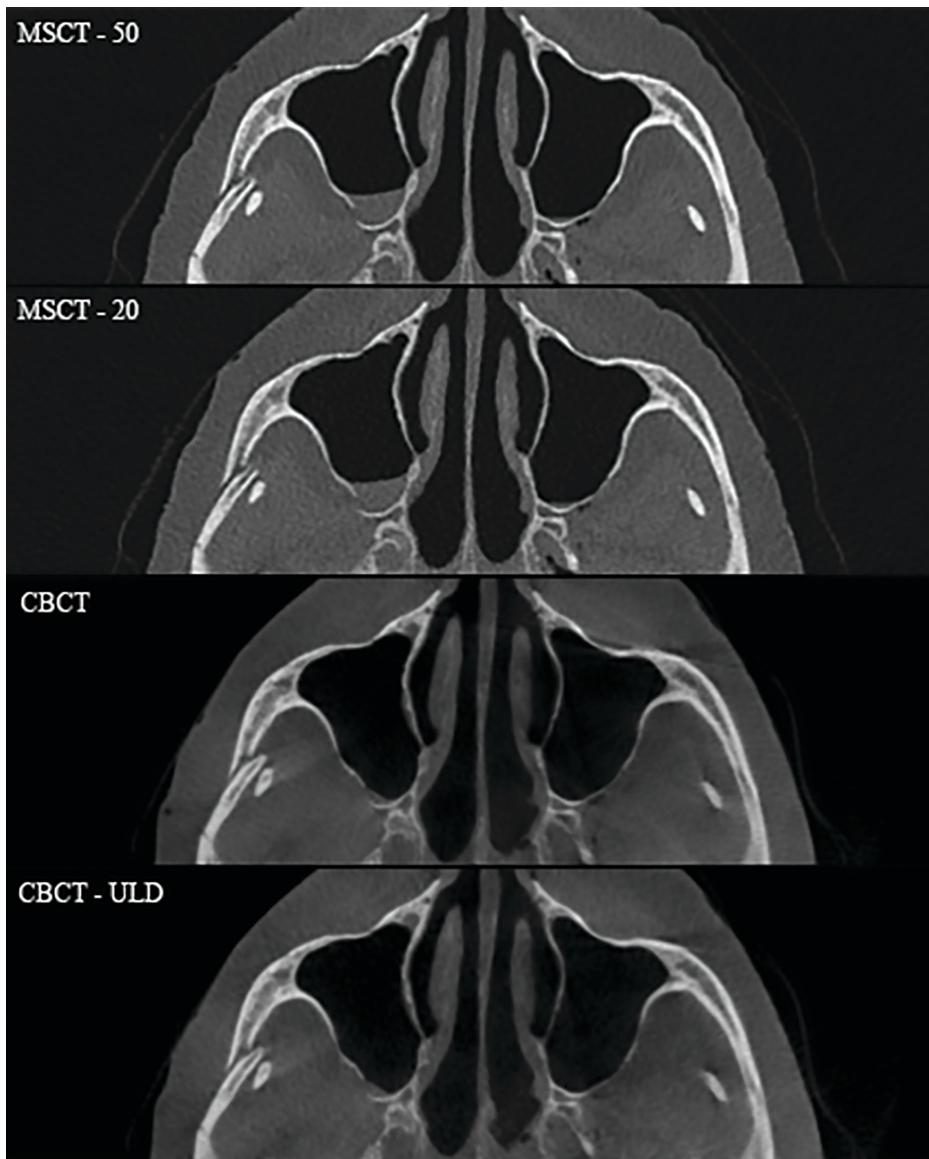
A right sided zygomaticomaxillary fracture in the zygomatic arch, the anterior and posterior sinus maxillary wall. The baseline (A+C) and the lowest dose (B+D) protocols for both Multidetector Computed Tomography and Cone Beam Computed Tomography are compared consecutively.
